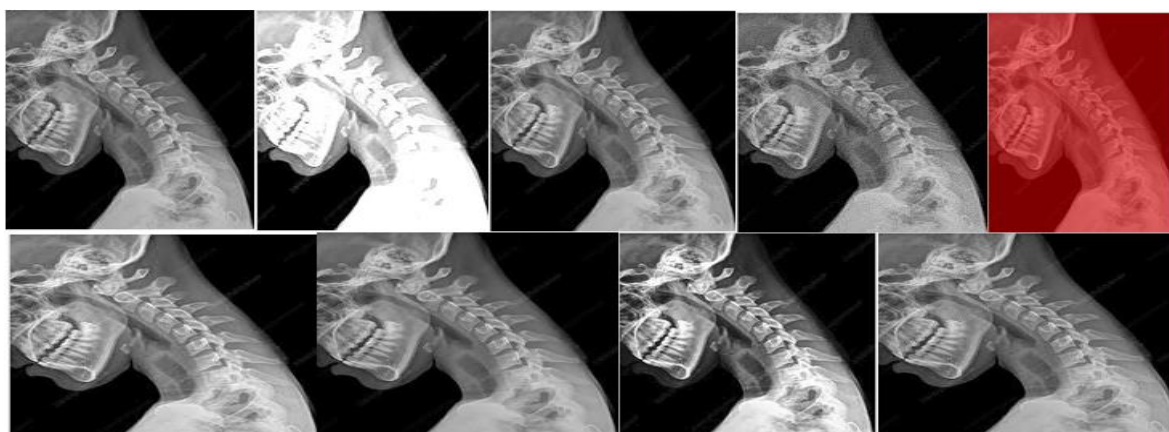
(a): part of neck radiographic basic color adjustment: from left, original image, modulated image to brightness of 200, modulated image to saturation of 150, modulated image to hue value of 150, quantized image to maximum value of 10 and colour-space gray, colored image with 50% red, enhanced image, median curve image and equalized image.
